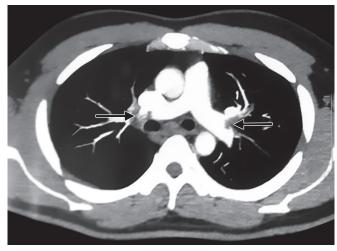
The CT pulmonary angiogram showing evidence of embolism in bilateral pulmonary artery (arrowheads)
